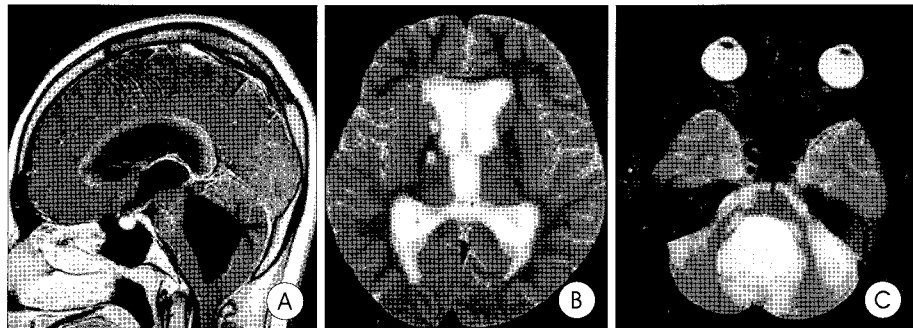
A : Preoperative T1-weighted sagittal magnetic resonance MR imaging demonstrates mild enlargement of third and lateral ventricles and markedly dilated fourth ventricle with aqueductal stenosis. B and C : Preoperative T2-weighted axial MR image reveals mild enlargement of lateral and third ventricles and marked dilatation of the fourth ventricle with periventricular edema.
